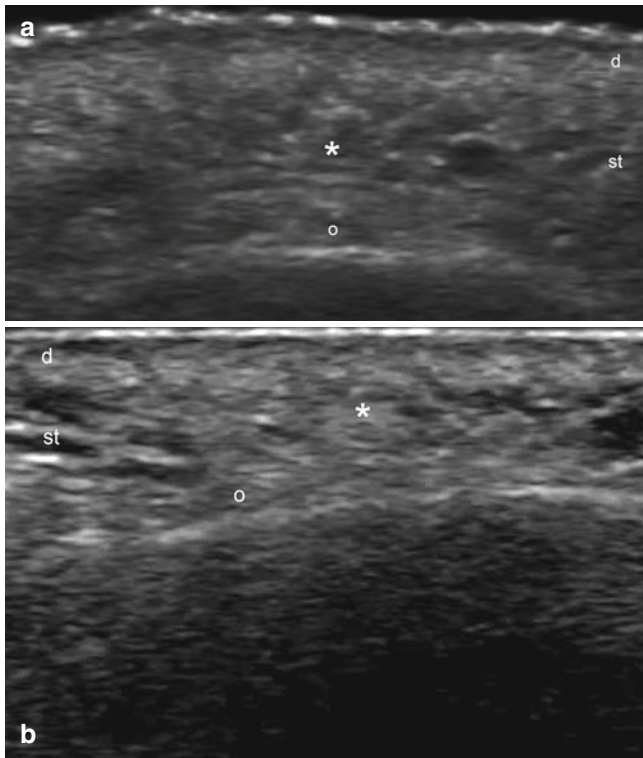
(a, b) Botulinum Toxin. Grey scale ultrasound images (transverse views; a glabellar region and b right superciliary ridge, moments after injection). There is an increased echogenicity of the subcutaneous tissue (*) and epicranium muscle (o) with blurriness of the margin of the layers at the sites of injection. *Abbreviations:* *d* dermis, *st* subcutaneous tissue
